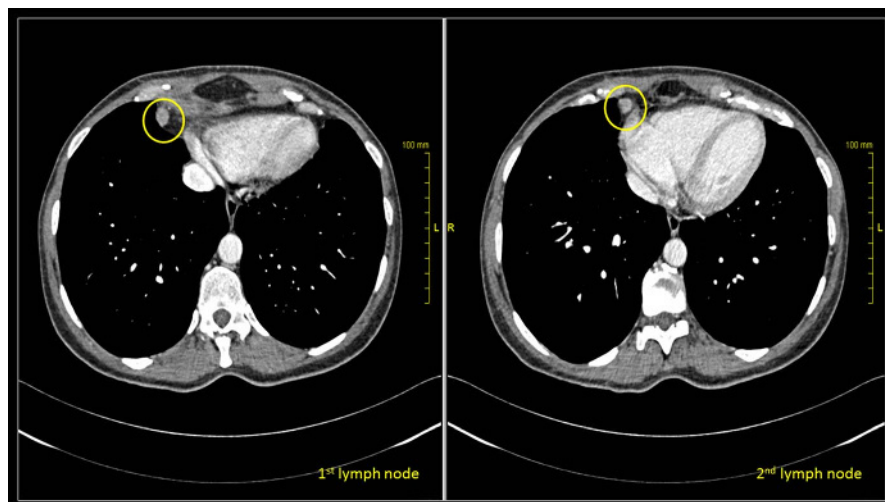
Computed tomography scan showing suspicious CPLNs (yellow loops indicate the lymph nodes).
